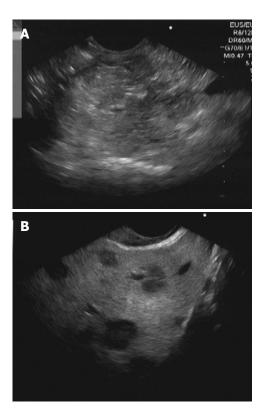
Endoscopic ultrasound findings. A: Echoview showed a large mediastinal mass; B: Liver nodules with target-like appearance were also observed.
